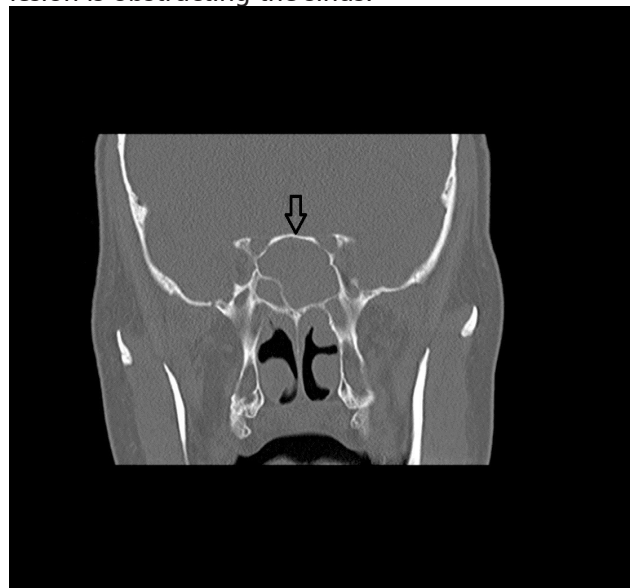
Coronal CT image. Sphenoid sinus is obliterated. No bony invasion is seen.
